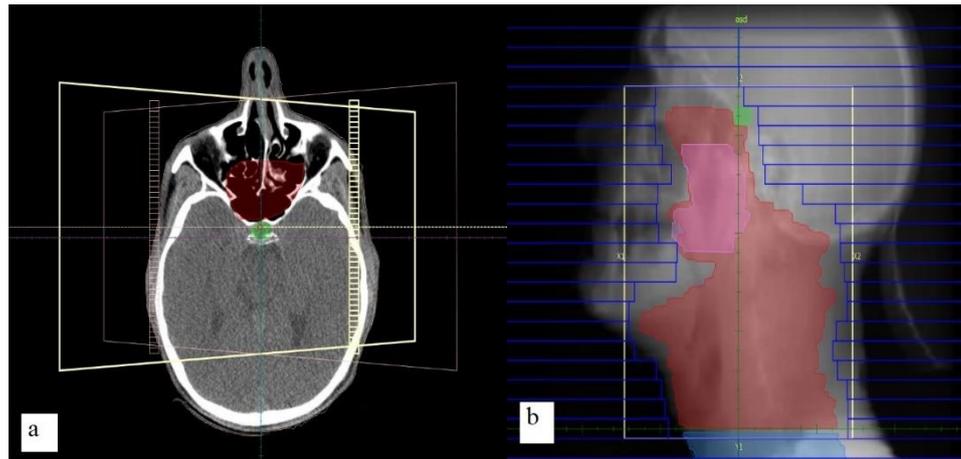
A sample treatment plan for a nasopharynx carcinoma, (a) the axial view and the tumor was depicted in red color, and the pituitary gland was in green. (b) A digitally reconstructed radiograph of the same nasopharyngeal tumor plus multi-leaf collimators depicted in blue color.
